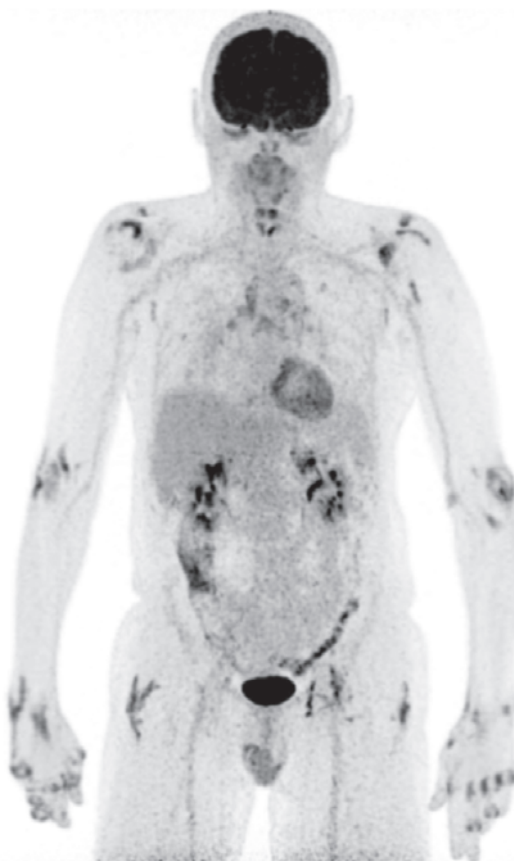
18-FDG PET scintigraphy performed on a 62-year-old patient for suspicion of a pulmonary tumor showing in fact a diffuse joint inflammatory process related to a psoriatic arthritis
